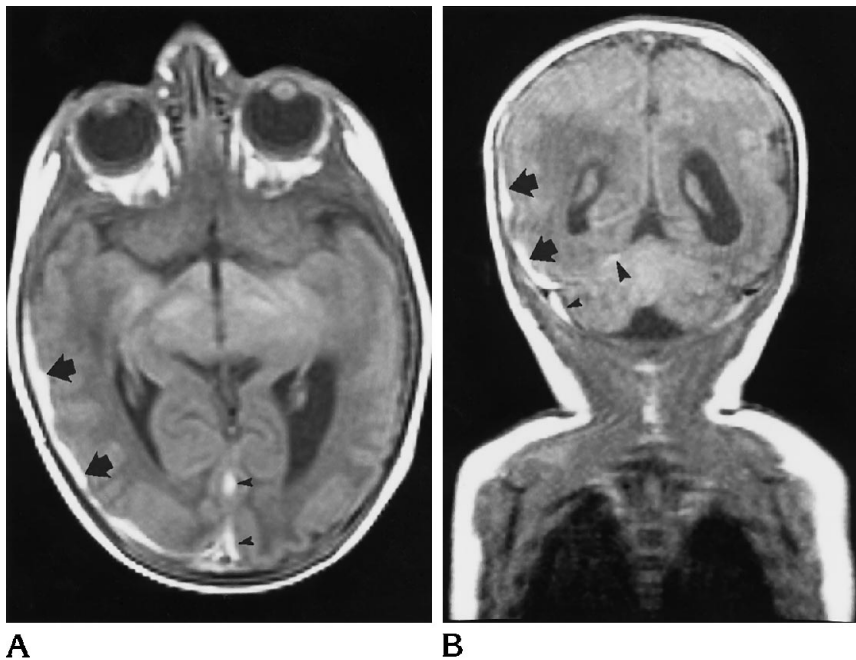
Case 1. A, Axial T1-weighted MR image shows a thin hyperintense subdural hematoma (arrows) along the right temporooccipital convexity with extension along the falx (arrowheads).
